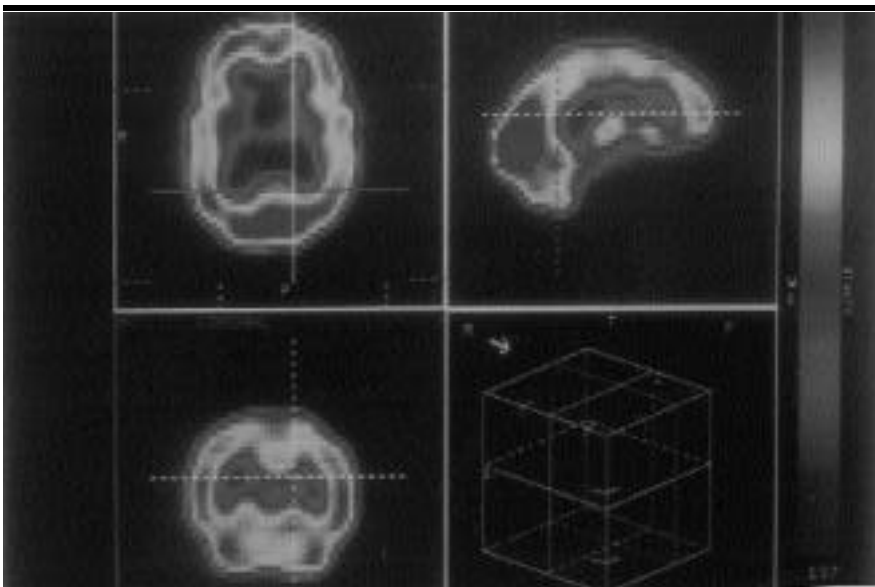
Cerebral SPECT scan of a patient with normal performances in all psychometric tests: note the normal perfusion of the whole brain.
